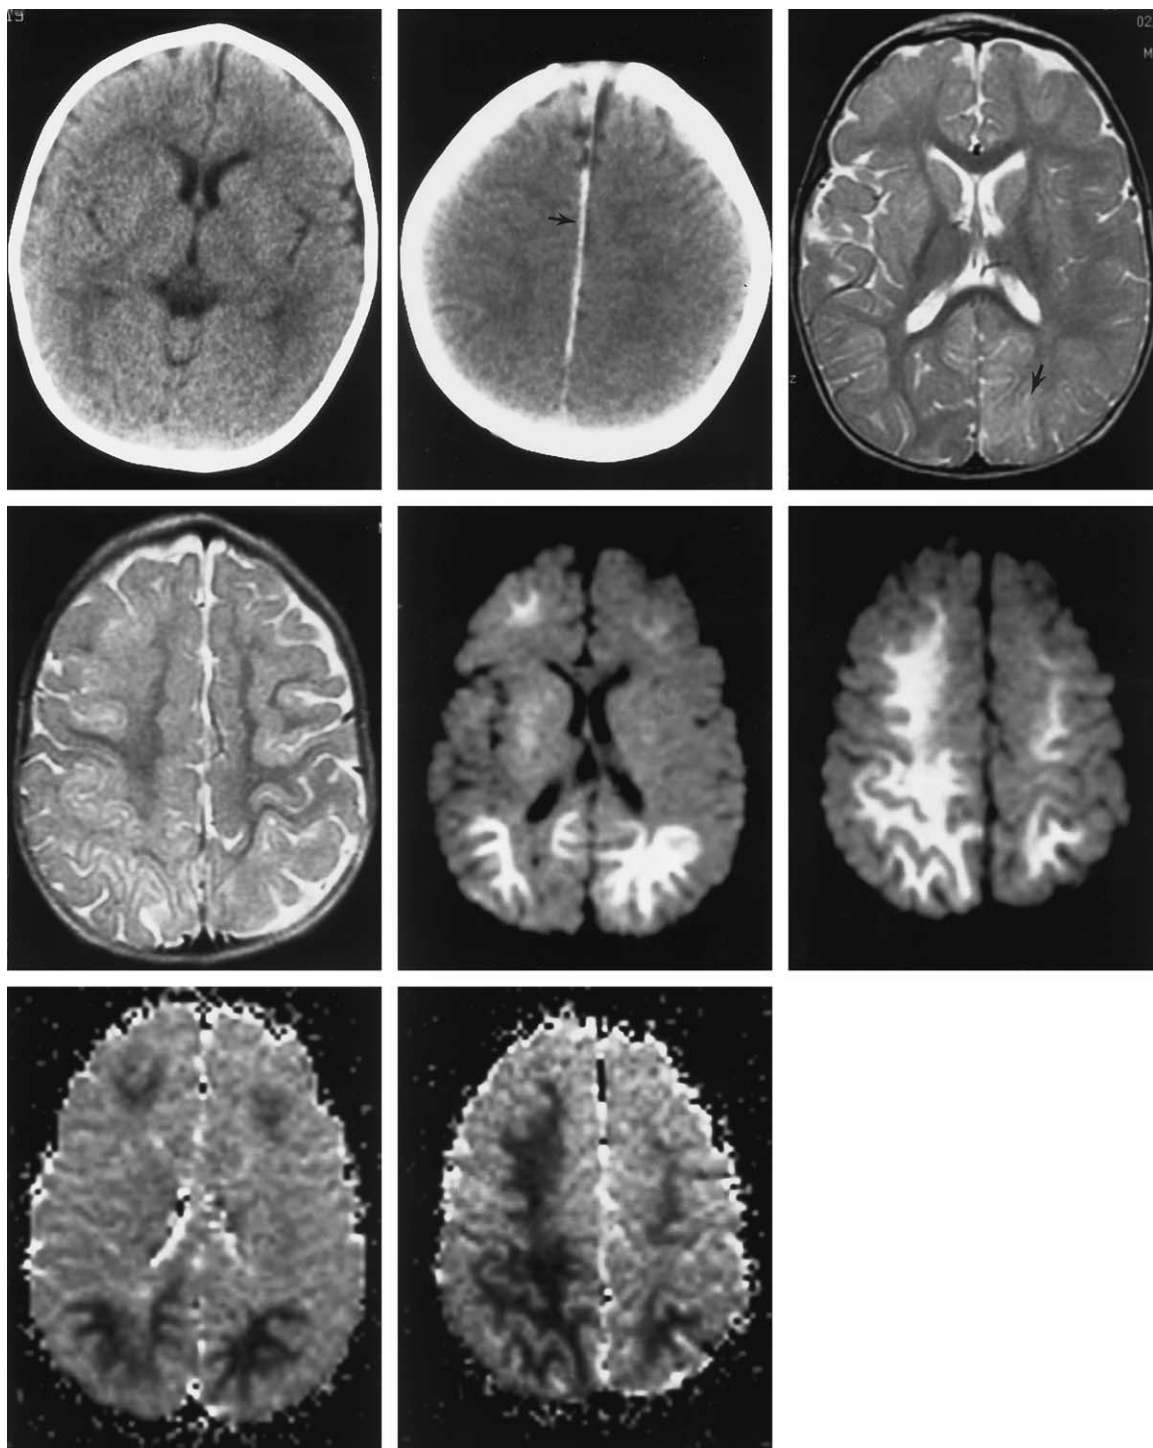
Noncontrast CT scan (top left and top middle), axial MRI-T2-weighted image (top right and middle left), diffusion-weighted image (middle middle and middle right), and the calculated ADC map (bottom left and bottom middle) in an 11 month-old child with confirmed SBS. The CT scan was obtained upon admission to the hospital and the DWI was performed 2 days later. There is an interhemispheric subdural hematoma (arrow) well seen on the CT scan (top middle). The T2-weighted images (top right and middle left) are remarkable only for possible cortical swelling involving the left occipital lobe (arrow). The DWI (middle middle and middle right) demonstrate symmetric hyperintensity involving the occipital lobes bilaterally, the right parietal lobe, and the posterior right frontal lobe. These hyperintensities on DWI correspond to decreased signal on the ADC map (bottom left and bottom middle), suggesting restricted diffusion. These abnormalities are consistent with bilateral watershed infarctions predominating in the occipito-parietal junctions. The magnetic resonance angiography showed normal intracranial arteries. The venous sinuses were normal on the conventional MRI.
